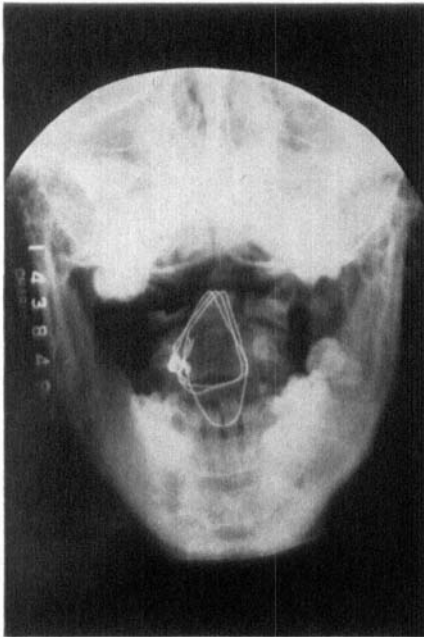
C and D. Patient no. 39 is a 46-year-old male whose admission x-rays (A and B) show anterior and lateral displacement. The patient had a posterior C 1, 2, 3 cervical fusion 2 weeks after sustaining the fracture. Figures C and D, which show union, were taken 8 weeks after surgery.
